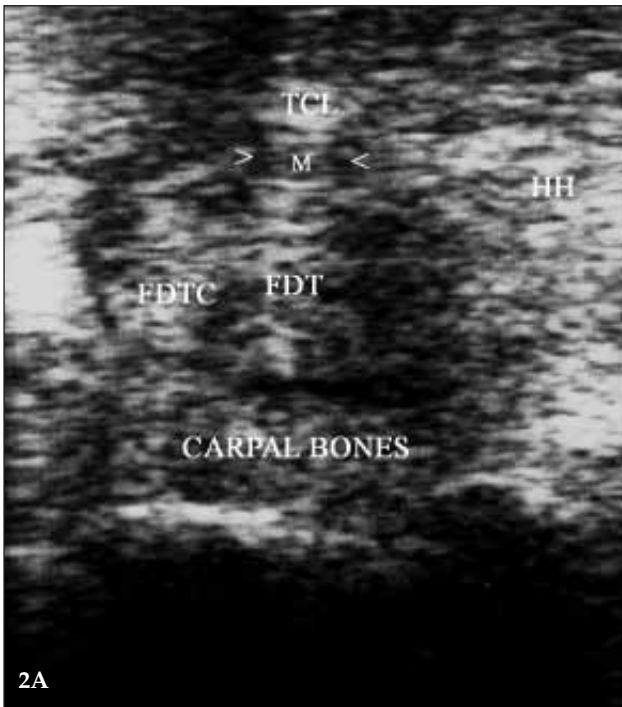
A. Ultrasonographic appearance of carpal tunnel contents in a CTS case (TCL: Transverse carpal ligament, HH: Hook of the hamate, MNC: Median nerve compartment, M: Median nerve, FTD: Flexor digitorum tendons, FDTC: Flexor digitorum tendons compartment) B. Ultrasonographic appearance of carpal tunnel contents in a normal case (TCL: Transverse carpal ligament, HH: Hook of the hamate, MNC: Median nerve compartment, M: Median nerve, FTD: Flexor digitorum tendons, FDTC: Flexor digitorum tendons compartment)
